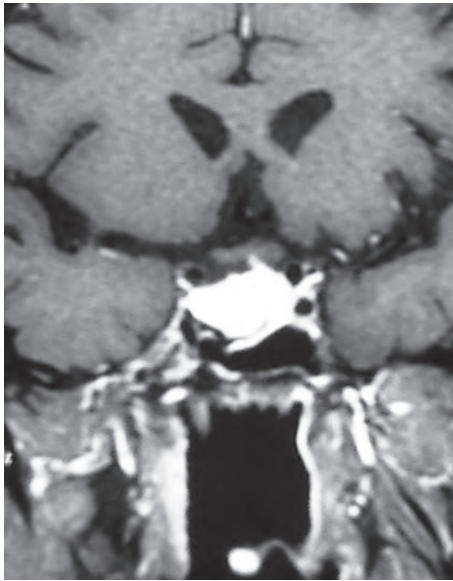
Coronal T1-weighted contrast MR image showing the sellar suprasellar Rathke's cleft cyst
